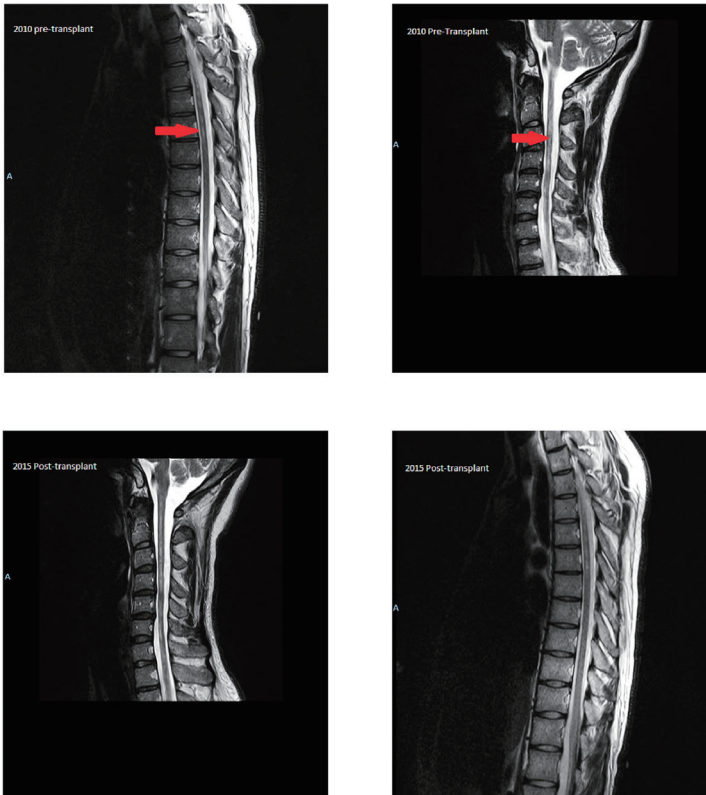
MRI cervical spine in 2010 (pre-transplant) showed diffused T2 weighted signals in the cervical and upper thoracic cord. Follow-up MRI spine done in 2015 (post-transplant) showed similar cervical and upper thoracic T2 hyperintensity.
